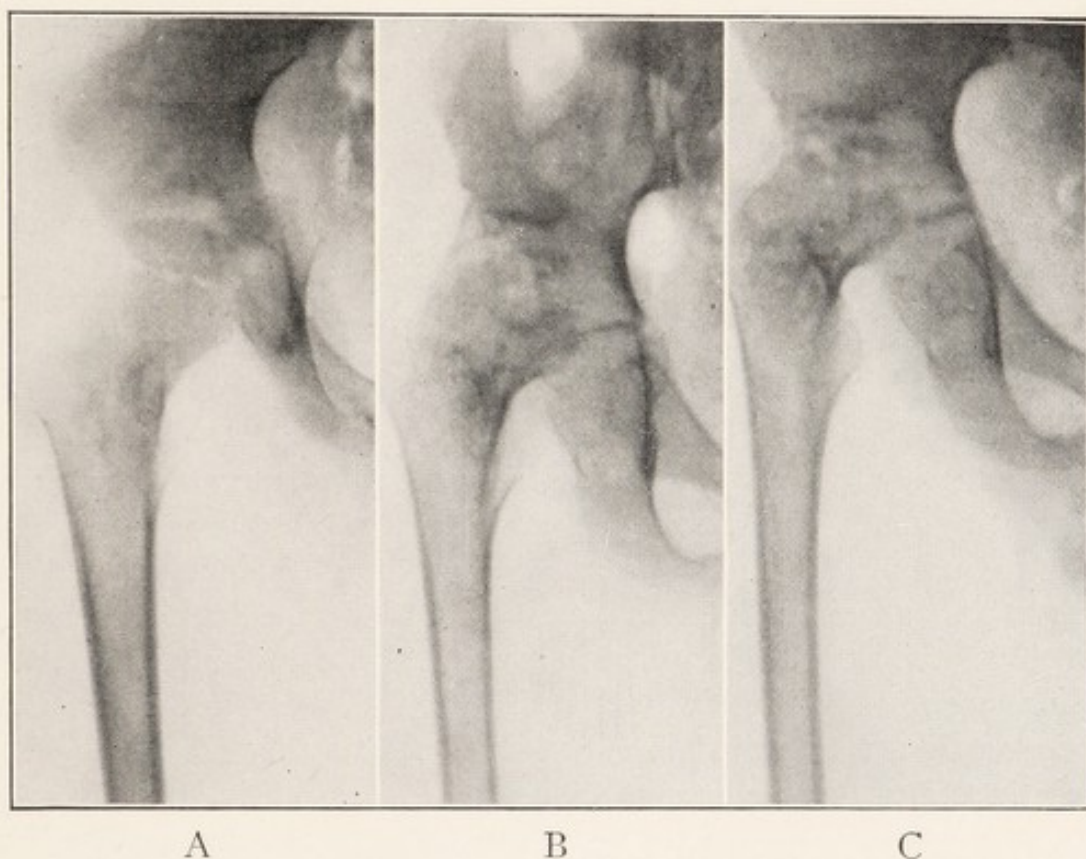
X-RAY SERIES SHOWING PROGRESSIVE DESTRUCTION OF TUBERCULOSIS OF HIP.
